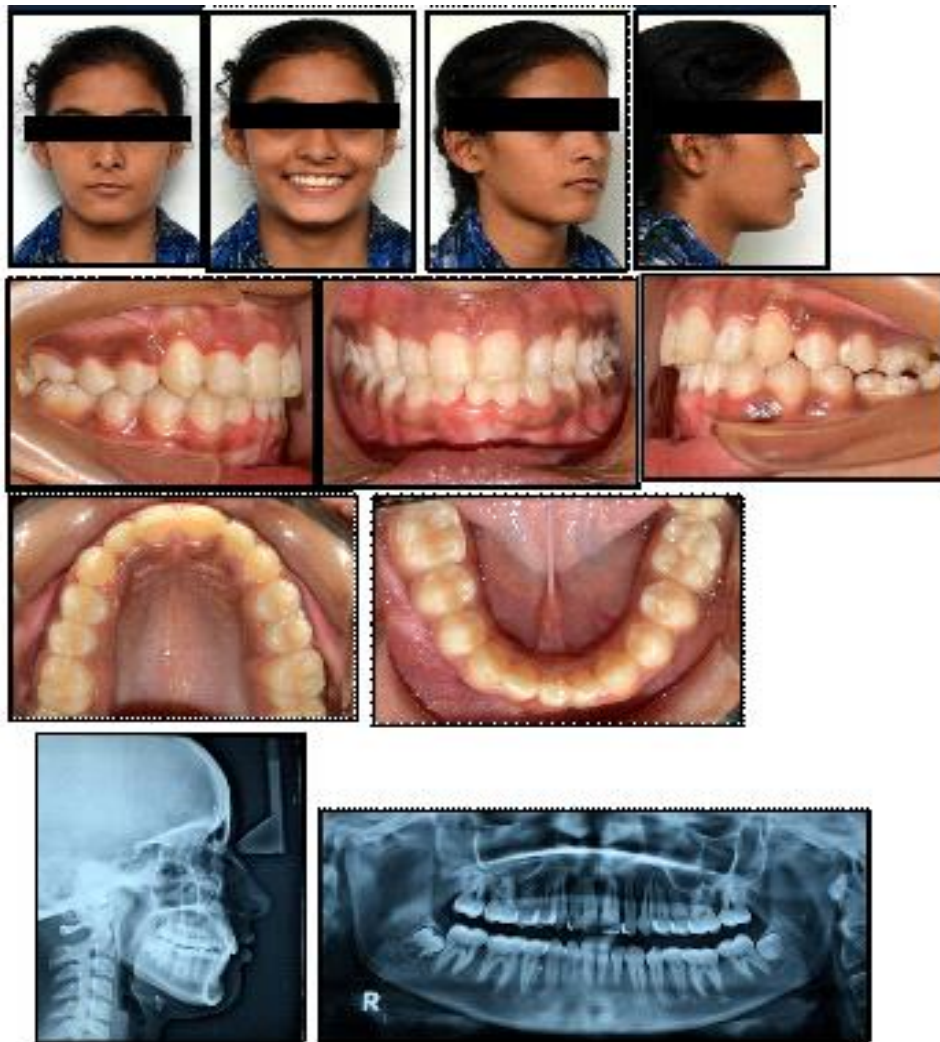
Post-treatment extra-oral and intra – oral photographs, radiographs
